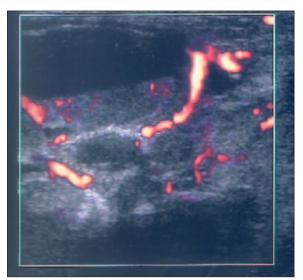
Typical sonographic appearance of ABC; fluid levels, vascularity of the septa.
